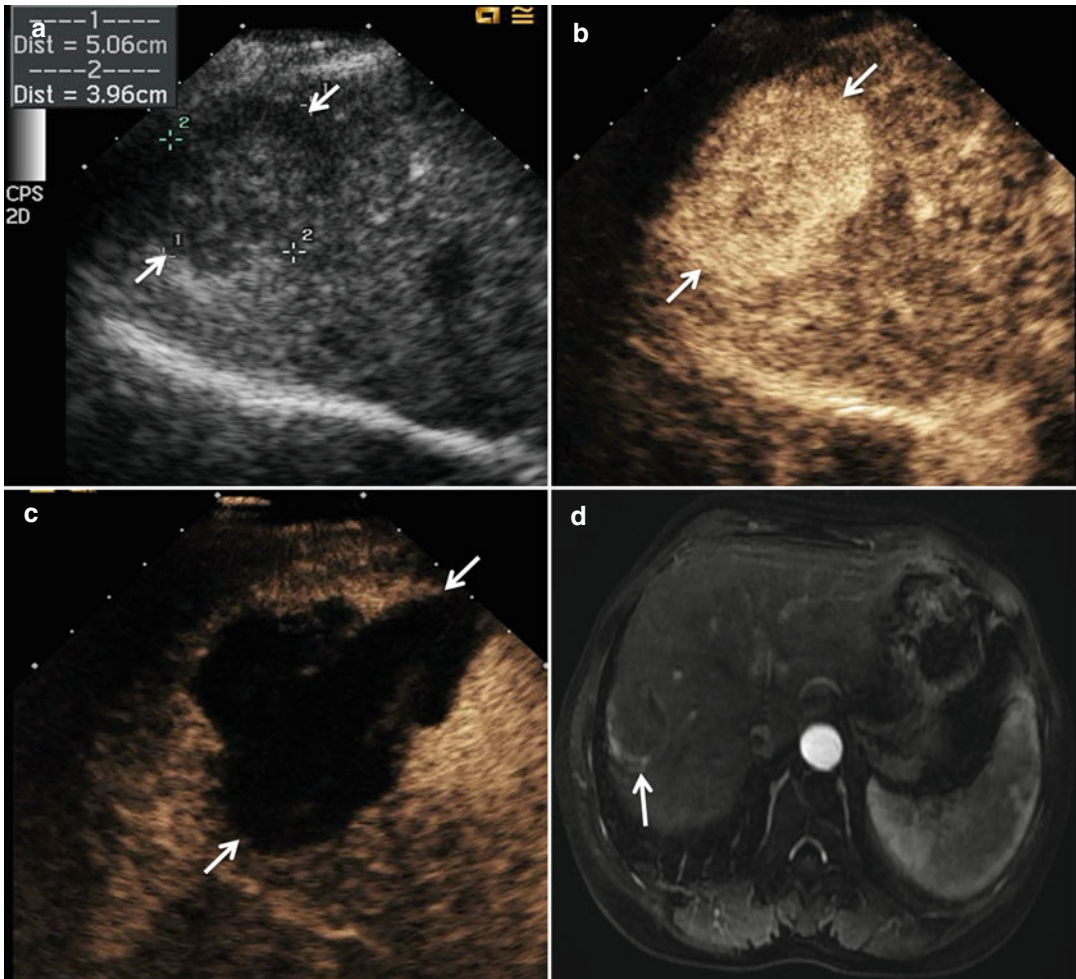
Microwave ablation (MWA) in a 55-year-old woman with HCC on right lobe of the liver (S8), who refuses to undergo hepatic resection. (a) Preablation conventional ultrasound (US) scan shows a hypoechoic lesion with poor blood supply (arrows). (b) Contrast-enhanced US before MWA shows tumor enhancement in arterial phase
